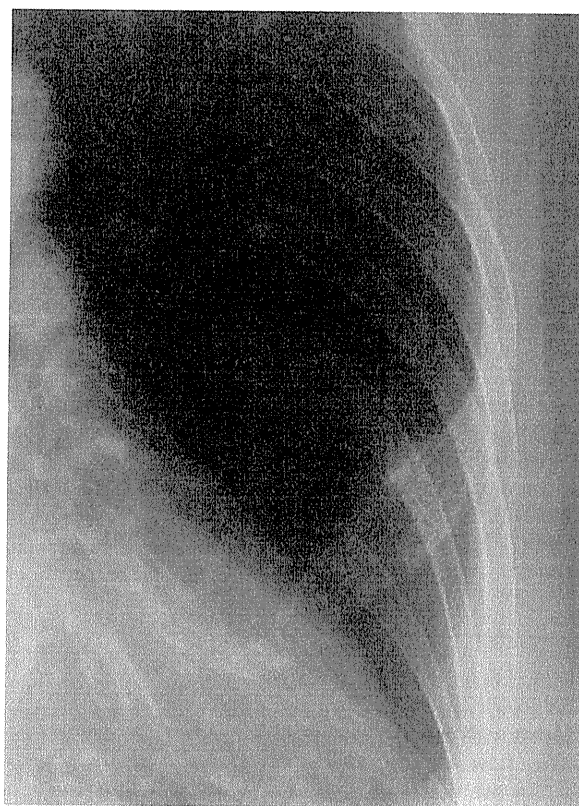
A chest roentgenogram showing an expansile lesion of the left fifth rib with sunburst-like appearance of extraosseous mass.
